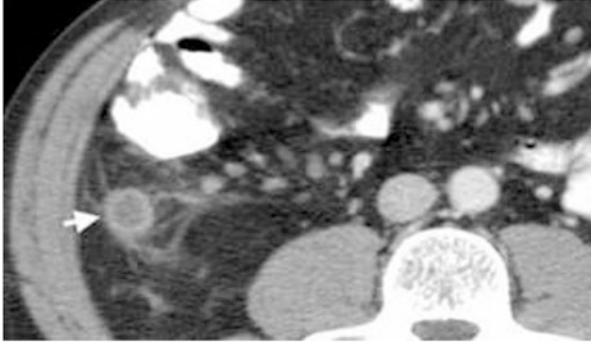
CT scan of the abdomen and pelvis showing an inflamed appendix with wall thickening and surrounding fat stranding
